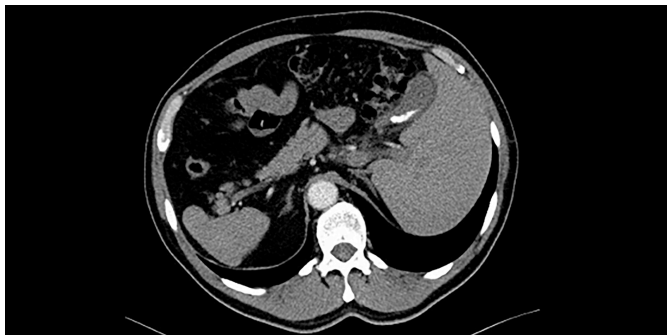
An image of abdominal CT scan shows multiple millimetric calculi inside of gallbladder.
